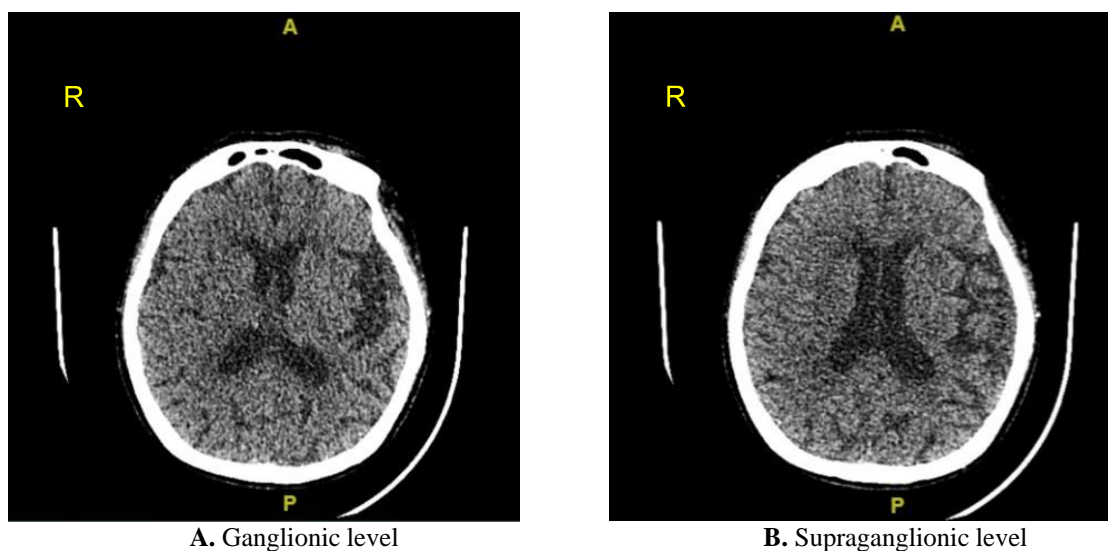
Head CT-scan of without contrast, no hypodensity or hyperdensity was found at the ganglionic (A) and supraganglionic (B) levels.
